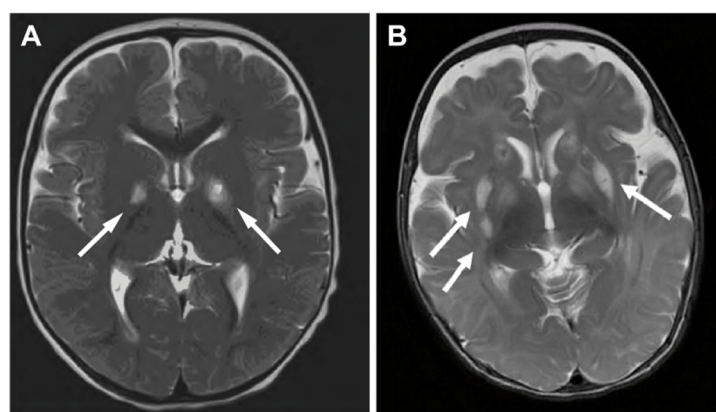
Magnetic resonance images (MRI) of the brain representing typical Leigh syndrome characteristics. Axial T2-weighted brain MRI of a 14-month-old girl with Leigh syndrome caused by complex III deficiency (A) and a 4-month-old boy diagnosed with Leigh syndrome (B) reveals bilateral lesions in the basal ganglia. Images adapted from (A) Baertling et al. 2013 and (B) Schubert Baldo and Vilarinho 2020.
